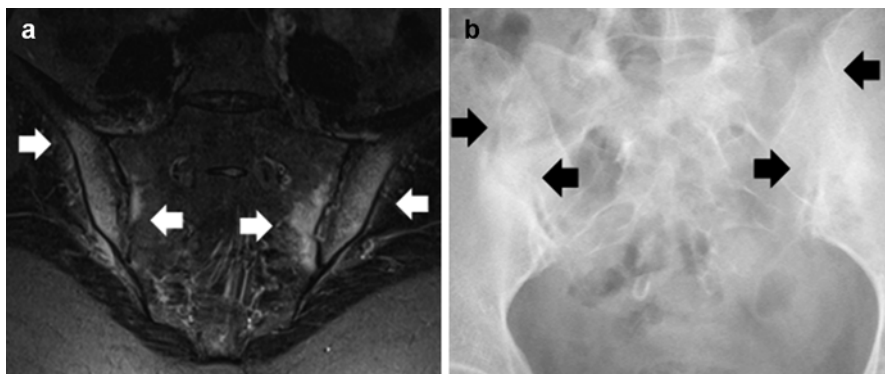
(a) MRI (STIR sequence) showing signs of disease activity. *White arrows*: oedema in the bone marrow. (b) Pelvic X-ray film showing bilateral sacroiliitis (*black arrows*), New York Criteria 3–4
